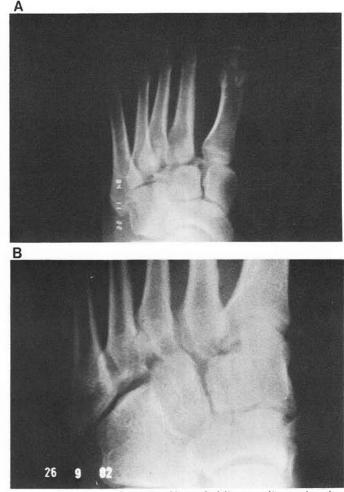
A. & B. Dorsoplantar and lateral oblique radiographs of type C injury. Careful scrutiny of medial cortical margin of second metatarsal and cuneiform will reveal a diastasis and avulsion fracture
